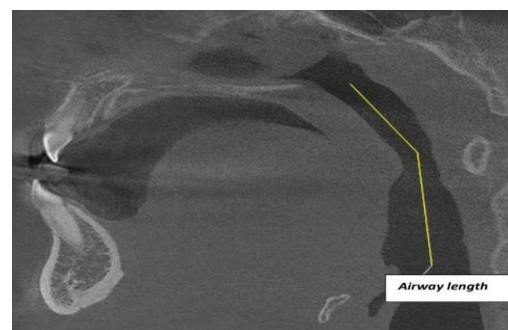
CBCT image of airway length
